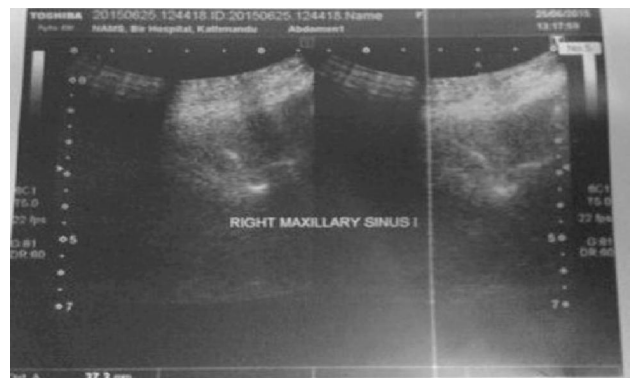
Ultrasound of right maxillary sinus showing clear visualization of all the walls of sinus with anechoic content within. The posterior wall echo distance is about 4 cm from the skin surface. Findings consistent with opacification of sinus.
